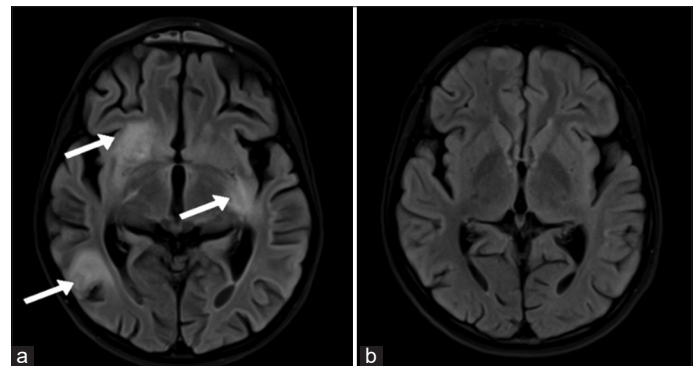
MRI brain, axial T2/FLAIR image showing abnormal cortical and subcortical hyperintense signal intensities in right temporal lobe, right hippocampus and in the left deep basal ganglia (a-White arrow); Follow-up MRI brain showing almost complete resolution of previously noted abnormal T2/FLAIR hyperintensities (b)
